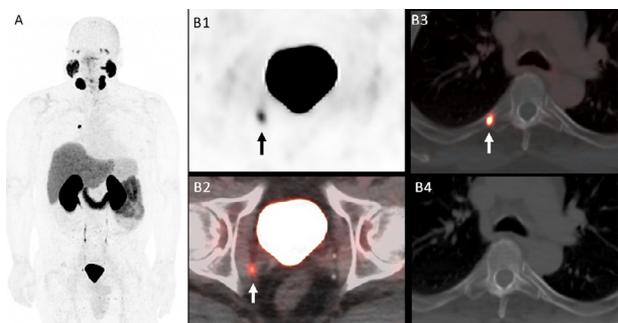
¹⁸F-DCFPyL PET/CT in a patient with biochemical recurrence PCa. A 63-year-old man with history of PCa, Gleason 9 (5 + 4), status post-prostatectomy a year ago, with rising PSA (0.44 ng/mL). Maximal intensity projection (A), axial ¹⁸F-DCFPyL PET, fused PET/CT, and CT images demonstrate a small 4 mm DCFPyL-avid right pelvic wall lymph node (B1 and B2), and a small focus of intense uptake at the posterior right fifth rib (B3), without definitive abnormality on the corresponding CT (B4). Biopsy was performed on the rib resulting in metastatic prostate cancer.
